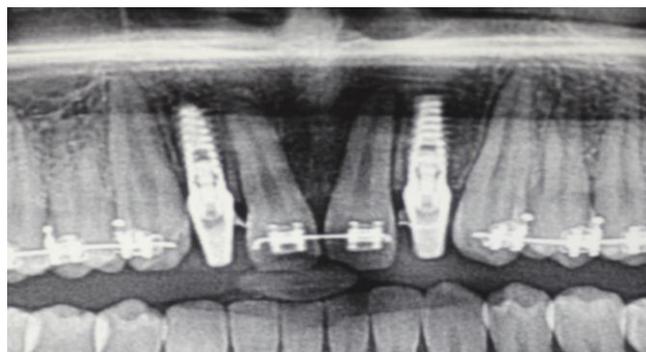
Radiograph after implant placement at right and left maxillary lateral incisor regions.
